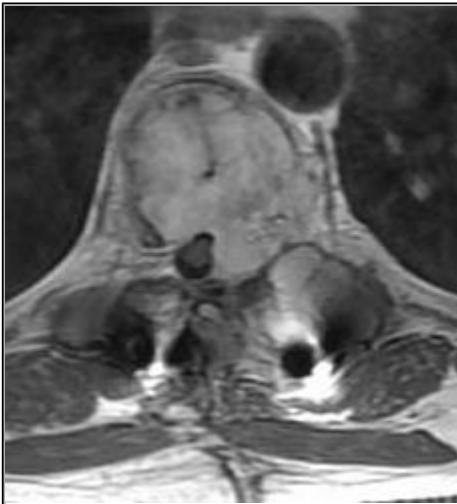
MR images, Axial plane
